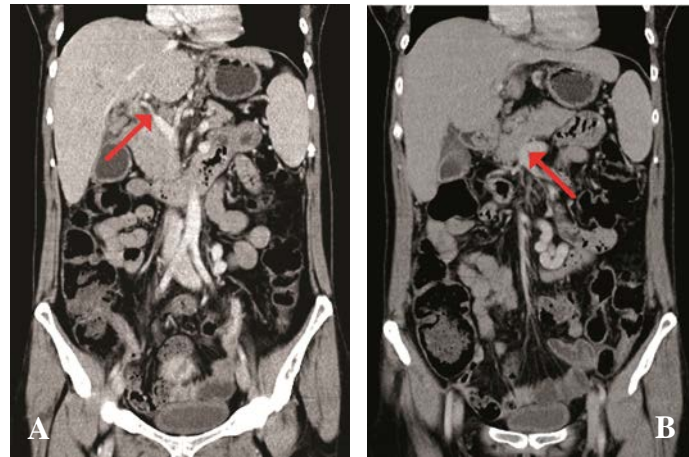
Preoperative computed tomography of patient No. 4. (A) The arrow indicates the portal vein. (B) The arrow indicates the confluence of the inferior mesenteric vein with the superior mesenteric vein
